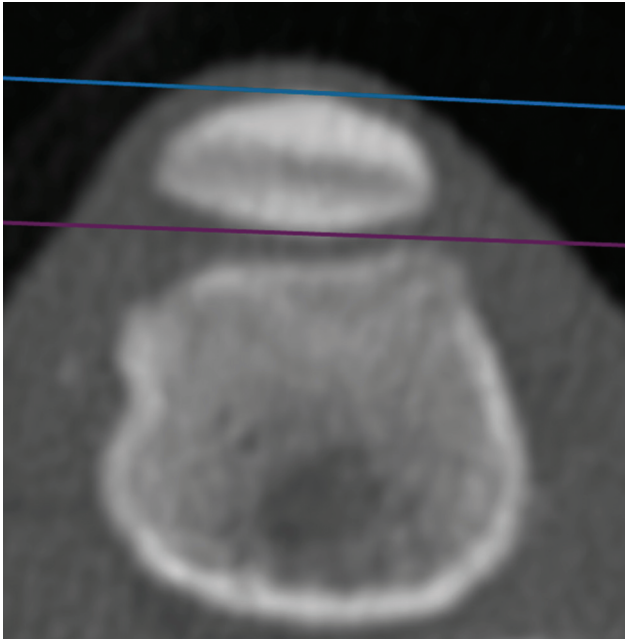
Transverse plane computed tomography scan demonstrating measurement of patellar thickness (P). A line was drawn across the cranial most part of the patella. A second line was drawn parallel to this at the most caudal part of the patella at its widest point. The patellar thickness was the difference between these.
